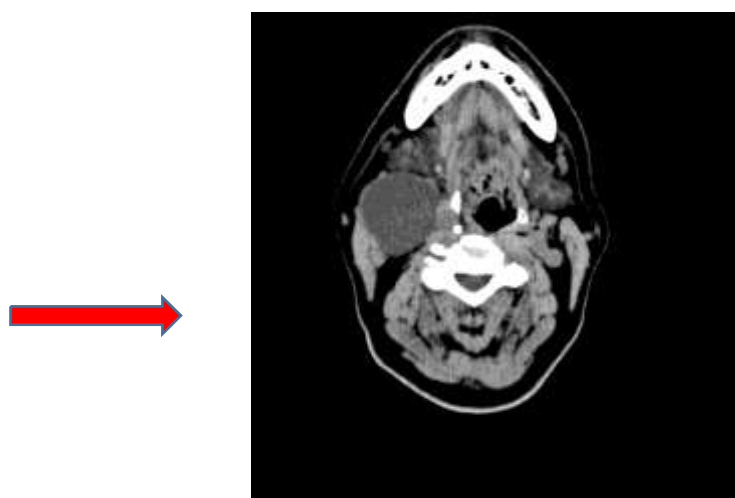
CT. The axial image shows a branchial cleft cyst.
